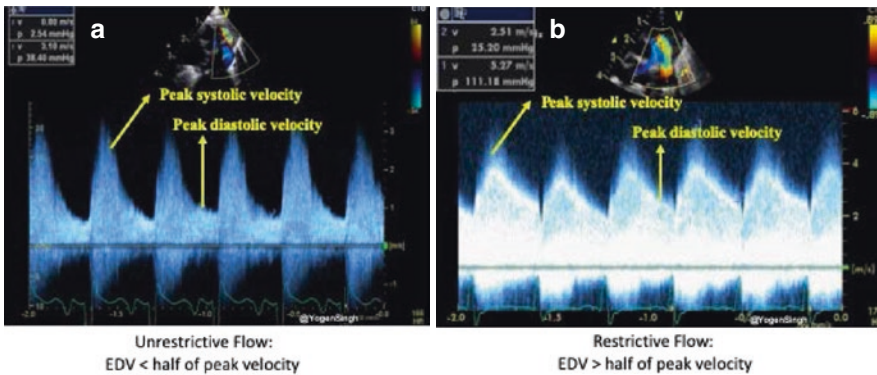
Assessment of restrictive and unrestrictive flow pattern on Doppler assessment of PDA. (a) Unrestrictive flow pattern with end-diastolic velocity (EDV) less than
